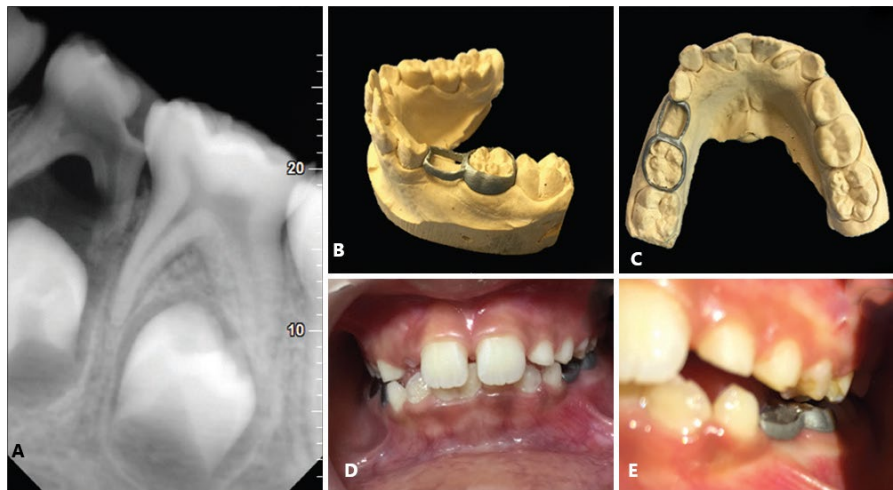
(A) Pre-operative radiograph of 74 revealing coronal radiopacity involving enamel, dentin, pulp and extending to the furcation, (B and C) 3D-printed metal-space maintainer on cast mold after registration, 3D-printed metal-space maintainer on cast mold after registration, 3D-printed metal-space maintainer in mouth (D and E) [17].
